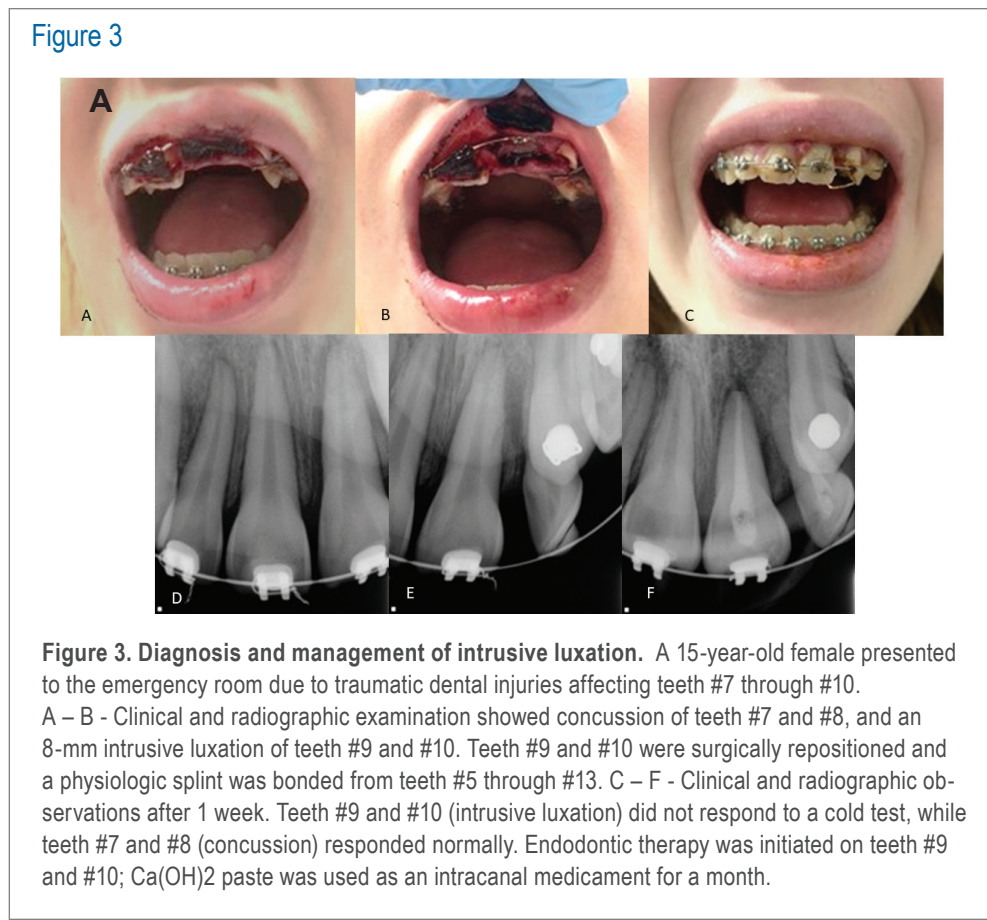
Diagnosis and management of intrusive luxation. A 15-year-old female presented to the emergency room due to traumatic dental injuries affecting teeth #7 through #10. A – B - Clinical and radiographic examination showed concussion of teeth #7 and #8, and an 8-mm intrusive luxation of teeth #9 and #10. Teeth #9 and #10 were surgically repositioned and a physiologic splint was bonded from teeth #5 through #13. C – F - Clinical and radiographic observations after 1 week. Teeth #9 and #10 (intrusive luxation) did not respond to a cold test, while teeth #7 and #8 (concussion) responded normally. Endodontic therapy was initiated on teeth #9 and #10; Ca(OH)₂ paste was used as an intracanal medicament for a month.
